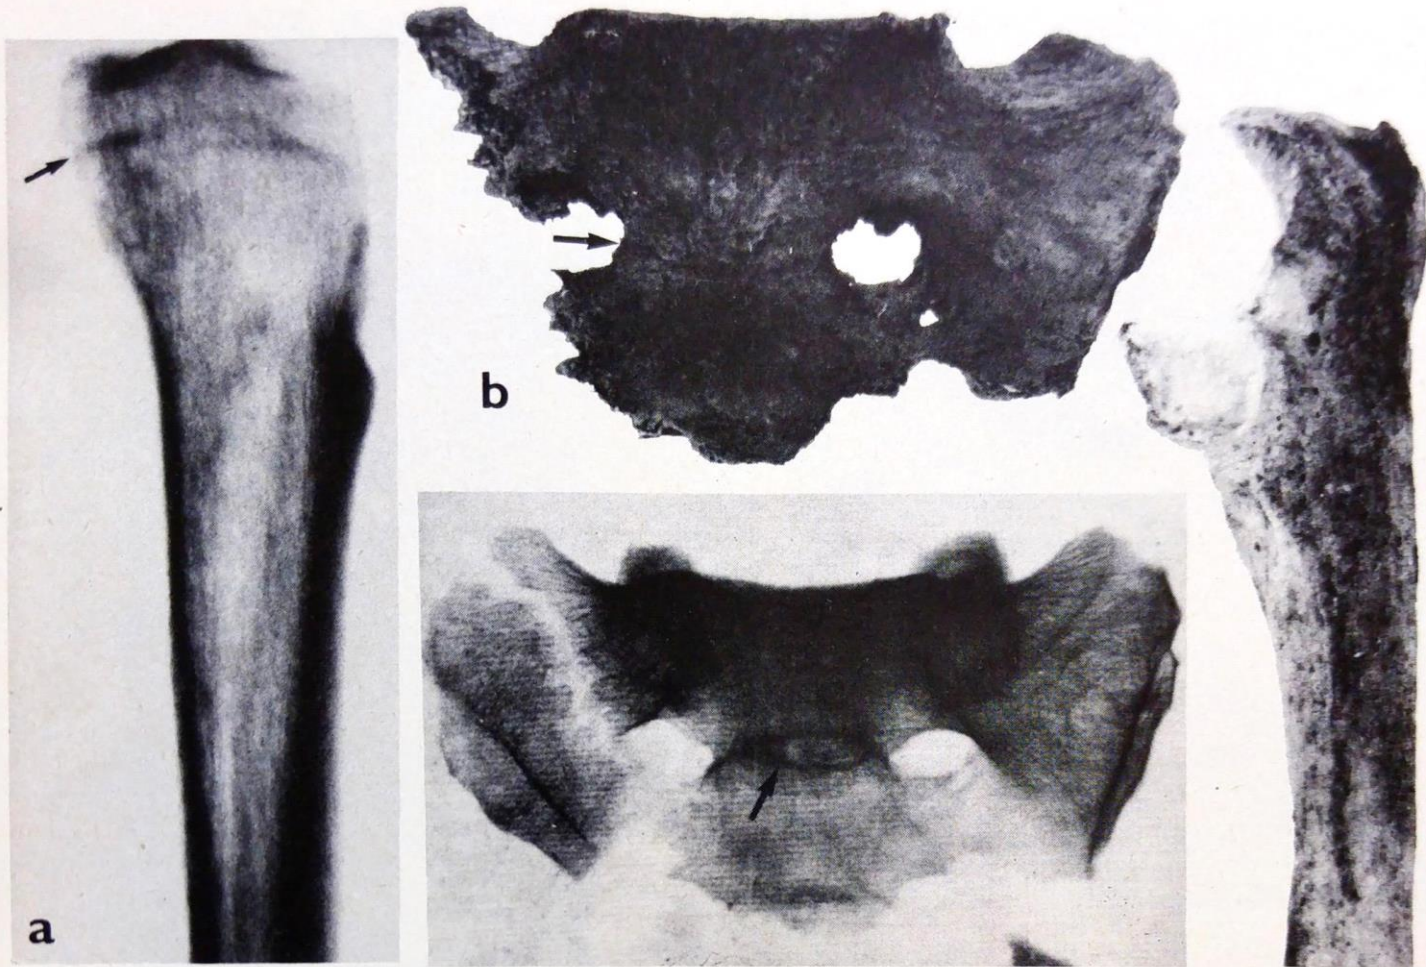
a) X-ray of the tibia bone shows the looseness of the spongy structure and traces of the ossified cartilage. b) Sacral bone with transversal line distinctly visible (photo by A. Klein).
